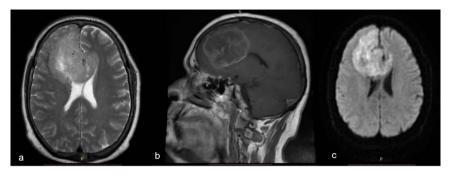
Cerebral MRI in axial T2 (a), sagittal T1 (b) and diffusion (c) sections, showing a frontal tissue lesion process associated with cerebral glioblastoma.
